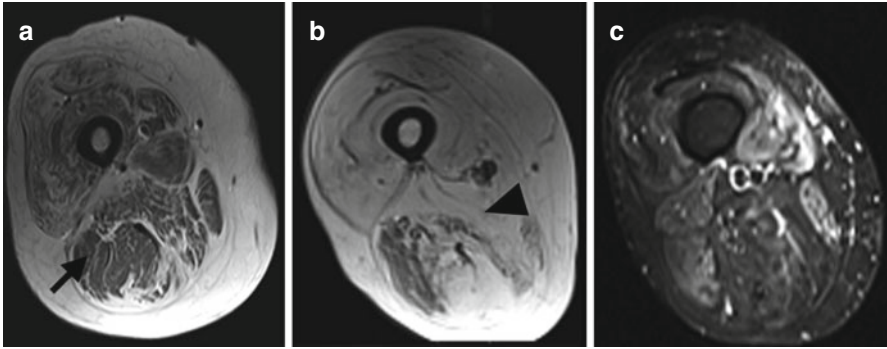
Right thigh *MRI* transverse images. (a): T1 weighted sequence age 57, (b): T1 weighted sequence age 60, (c): *STIR* (short-tau inversion recovery) sequence age 60. In (a) there is fatty atrophy greater anterior than posterior, with relative preservation of biceps femoris (*arrow*). In (b) taken 3 years later there is clear progression of fatty infiltration, particularly in adductor magnus (*arrowhead*). Hyperintensity within muscles in (c) demonstrated abnormal water accumulation within muscles suggesting active disease
